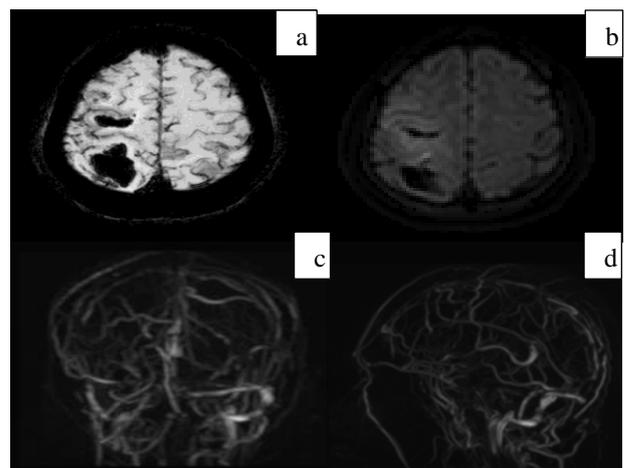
SWI and DWI showing haemorrhagic infarcts in the right frontal and parietal lobes; (c) and (d): MRV shows loss of normal flow voids with filling defects in superior sagittal, right transverse, sigmoid sinuses, internal jugular vein and distal straight sinuses.
